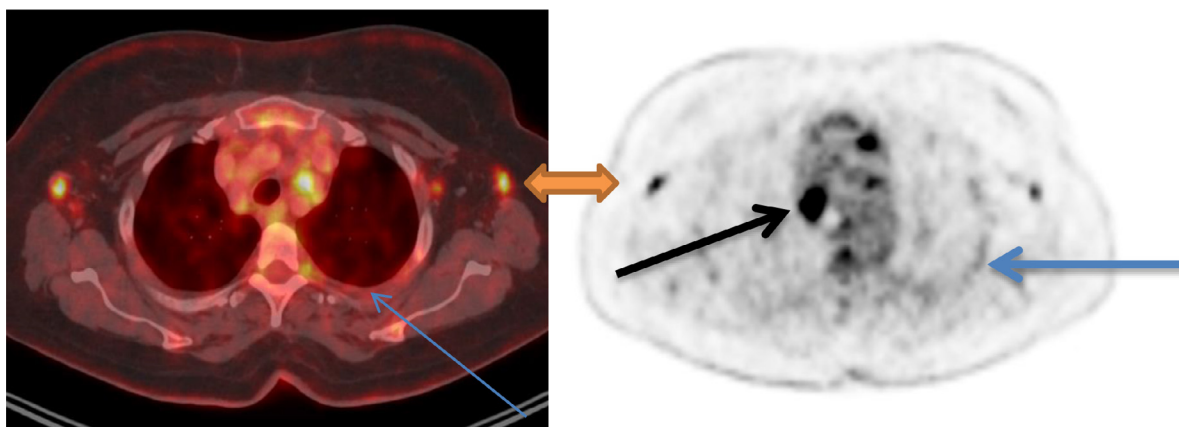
PET [right] and PET-CT fusion images [left] axial sections showing the increased uptake in the axillary lymph node SUV max = 6.2 (green arrow) and the mediastinum (biopsied lymph node) SUV max = 11.8 (black arrow) plus mild pleural uptake SUV max = 3.2 (blue arrows).(Color version is available online).
